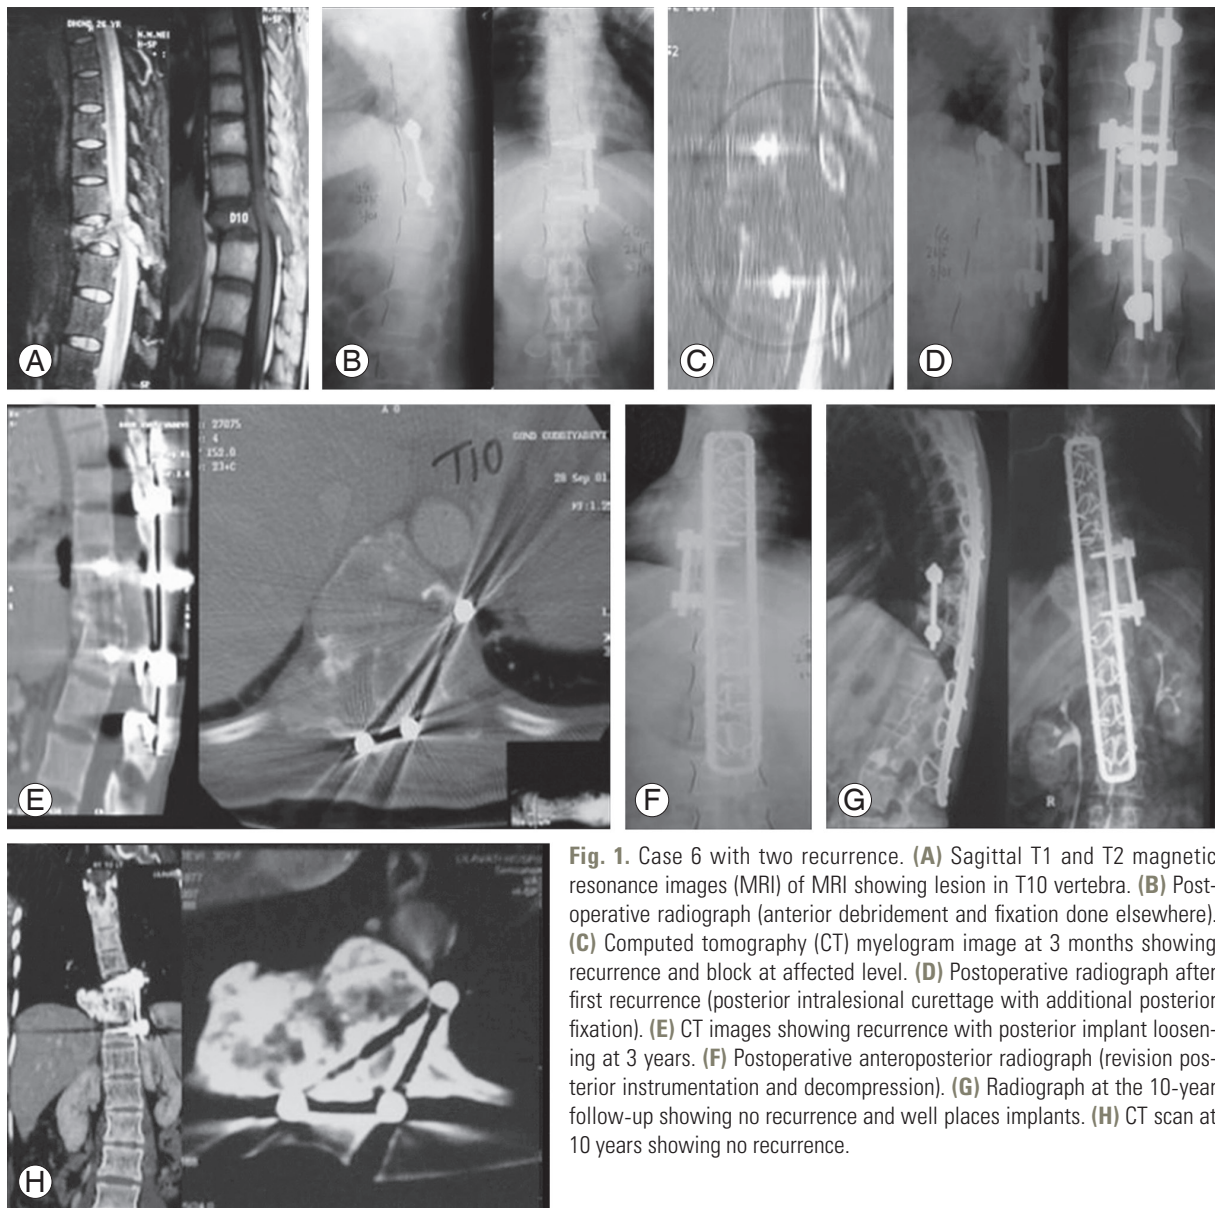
Case 6 with two recurrence. (A) Sagittal T1 and T2 magnetic resonance images (MRI) of MRI showing lesion in T10 vertebra. (B) Postoperative radiograph (anterior debridement and fixation done elsewhere). (C) Computed tomography (CT) myelogram image at 3 months showing recurrence and block at affected level. (D) Postoperative radiograph after first recurrence (posterior intralesional curettage with additional posterior fixation). (E) CT images showing recurrence with posterior implant loosening at 3 years. (F) Postoperative anteroposterior radiograph (revision posterior instrumentation and decompression). (G) Radiograph at the 10-year follow-up showing no recurrence and well places implants. (H) CT scan at 10 years showing no recurrence.
